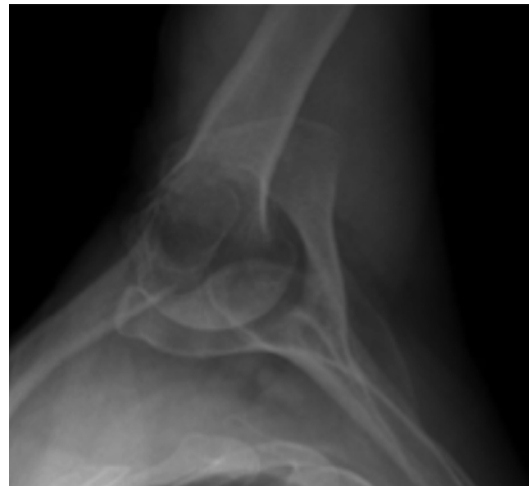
Compromise of the anterosuperior rotator cuff results in static anterior subluxation (anterior escape) that is apparent on the axillary radiograph (Reproduced with permission from Gartsman and Edwards [13], pp 219–221)
